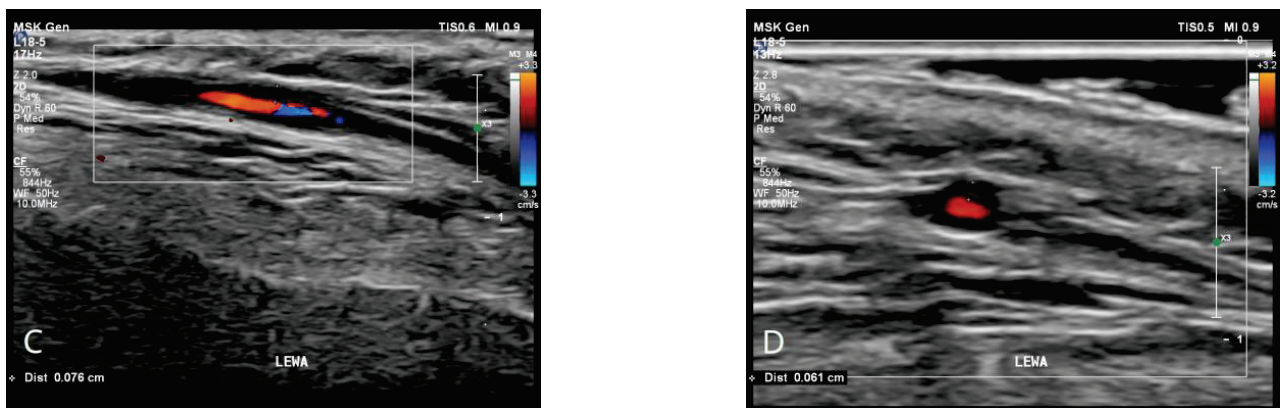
Ultrasonographic imaging of the temporal artery. Comparison of ultrasound images of an unchanged temporal artery (A) and inflammation of the temporal artery in giant cell arteritis (B). Both longitudinal (C) and transverse (D) views of the inflamed artery reveal the narrowing of the arterial lumen and homogenous, hypoechoic wall thickening (white markers), well delineated towards the luminal side, known as the “halo sign” [5].
